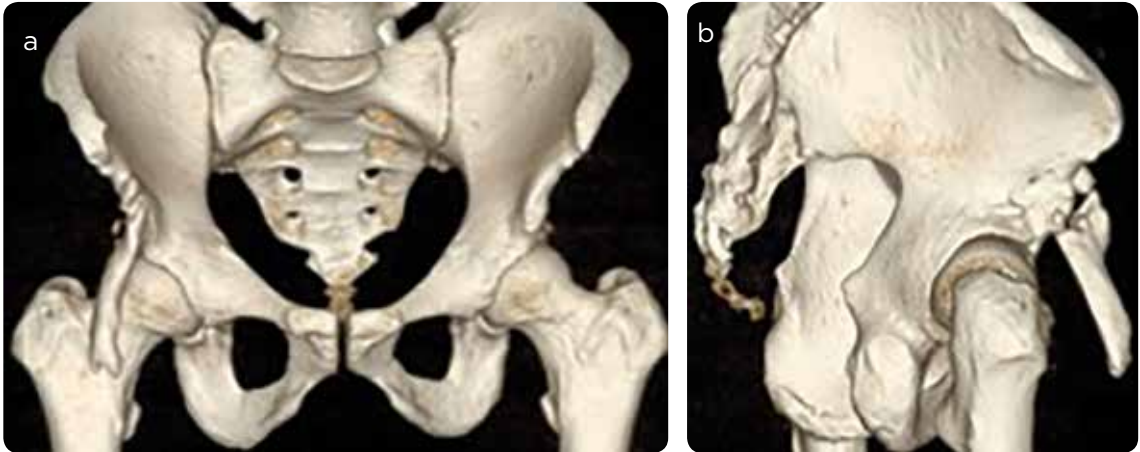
Three-dimensional reconstructions of hip CT: show a pseudoarticulation of the pelvic finger with the right acetabular roof.
